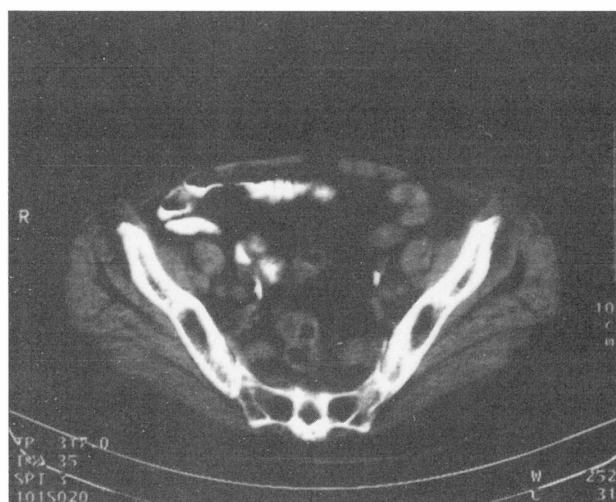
CT finding after the end of treatment - there is no evidence of the previous metastasis to the left ovary.
